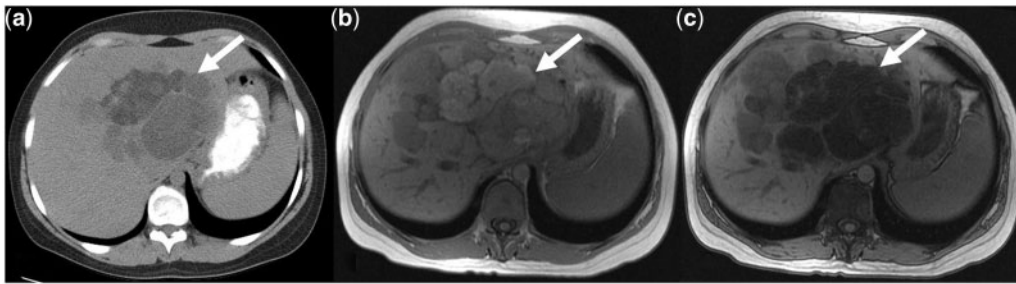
Fatty HCC. Unenhanced CT (a), in-phase (b) and opposed phase (c) MR images in the same patient showing heterogeneous HCC with fat component (arrow).
